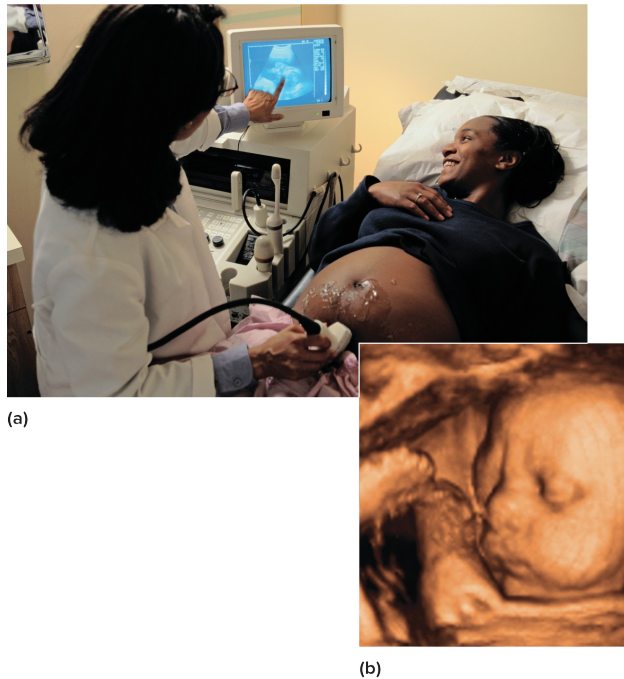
Sonography. (a) Producing a sonogram. (b) Three-dimensional sonogram of a fetus at 32 weeks of gestation.
